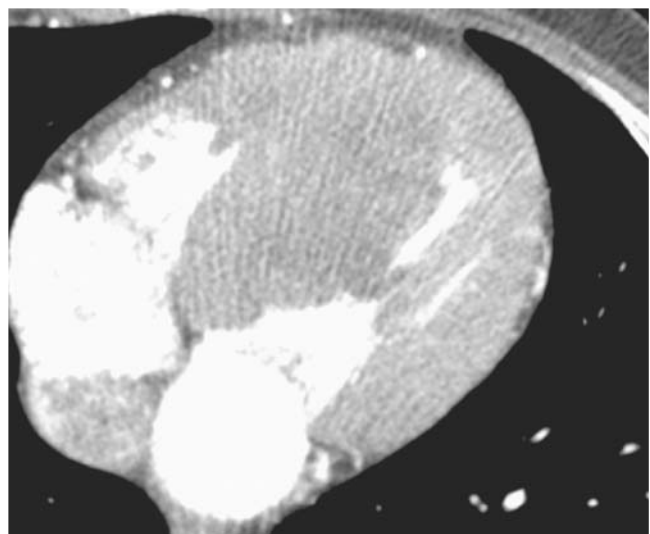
CT angiogram demonstrating hypertrophic cardiomyopathy with a profoundly hypertrophied septum.
